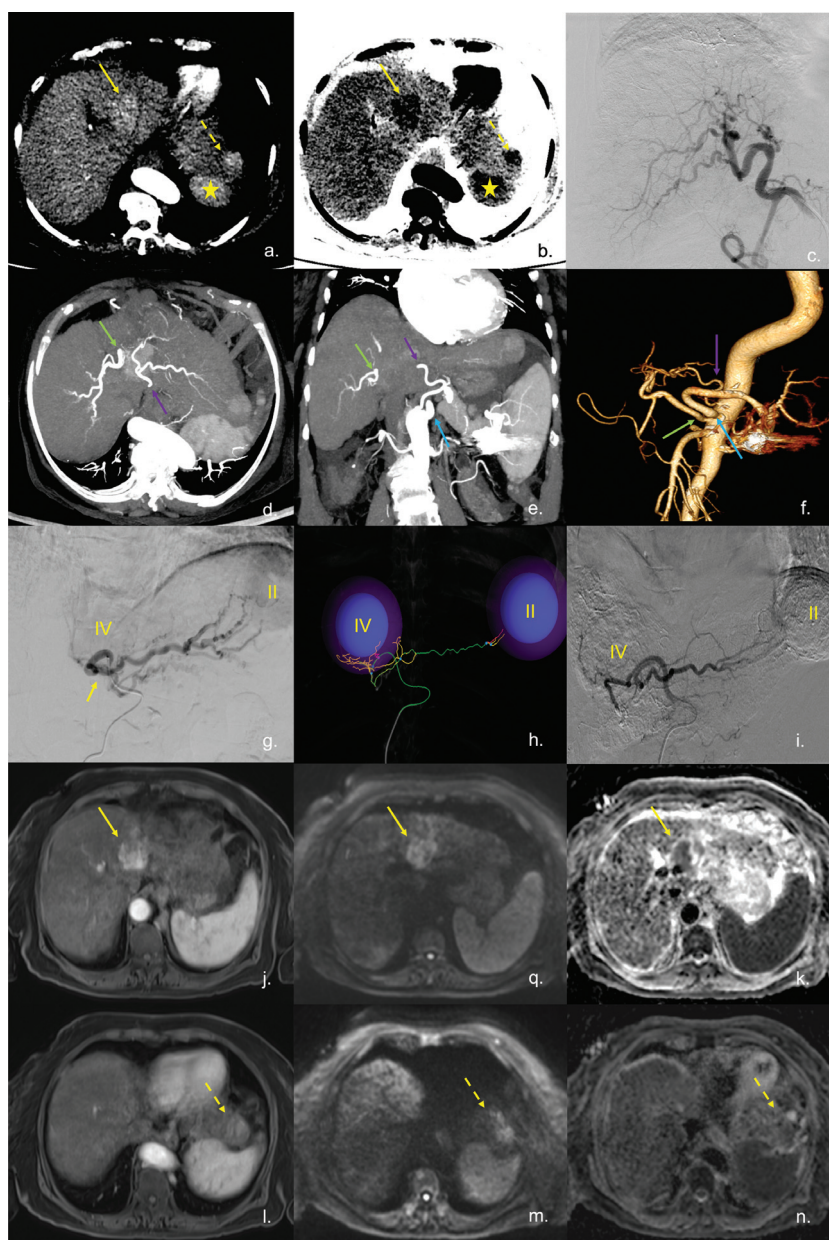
A 72-year-old cirrhotic patient due to hepatitis C, multifocal hepatocarcinoma, Child–Pugh A–5 points, ECOG 0, BCLC B, in systemic including antiviral treatment, now with new lesions. Control tomography showed (a, b) lesions in liver segments II and IV consistent with known hepatocarcinoma; image a in conventional gray scale, image b in inverted gray scale to make the lesions conspicuous and easier to identify them. Continuous yellow arrow indicates the segment IV lesion and the dashed arrow indicates the segment II lesion; the asterisk indicates the spleen. (c) Angiography with DEB-TACE attempt where lesions were not clearly circumscribed. The procedure is finalized and CT angiography was performed to characterize lesions, vascularization, and for new therapeutic planning. (d–f) Anatomical variant of the celiac trunk with independent emergence of the hepatic artery (green arrow), splenic artery (blue arrow), and left gastric artery (purple arrow), the latter being responsible to irrigate previously documented segment II and IV lesions. Based on this, a new chemoembolization procedure is scheduled (g–i), it was performed with selective cannulation of the left gastric artery and embolization was performed with the assistance of the EmboGuide system, which was finally satisfactory. (g, h) Yellow arrow indicates the independent origin of left gastric artery; number “IV” corresponds to lesion of segment IV and the number “II” is the lesion of hepatic segment II; this same numbering is used in the “i” image to show the already embolized lesions. (j–n) Three months MRI control after DEB-TACE. mRECIST was considered *stable disease*. Continuous yellow arrow in j, q, and k corresponds to embolized lesion of segment IV in contrast enhanced T1 sequences, diffusion B800 and ADC respectively. The discontinuous yellow arrow in l, m, and n corresponds to embolized lesion of segment II in contrasted T1 sequences, B800 diffusion and ADC respectively, where early enhancement and diffusion restriction of both lesions are evident.
